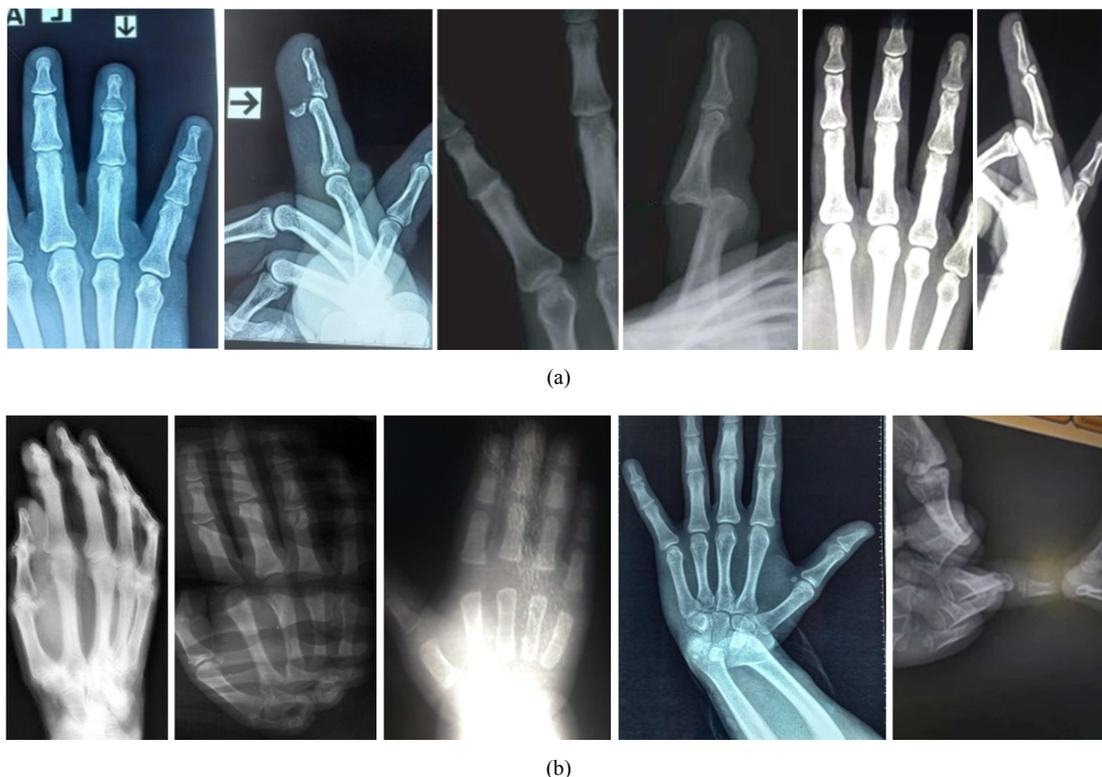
(a) demonstrates how misleading a single X-ray view can be; (b) shows that reliance on non-standard X-ray views can be a cause of error.
